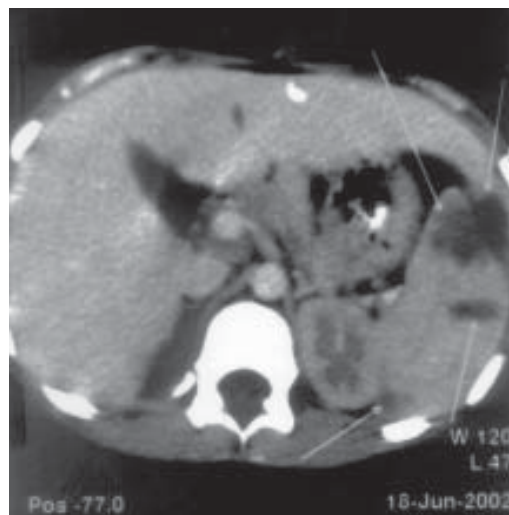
CT scan abdomen showing splenomegaly with multiple well defined irregular hypodense non-enhancing areas.
